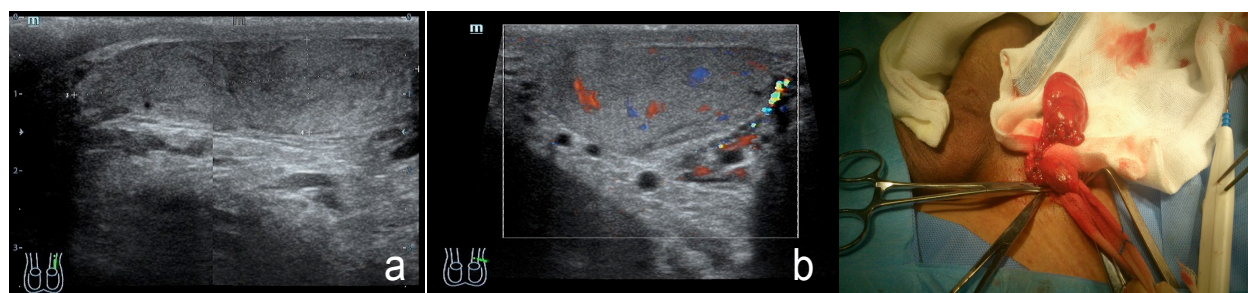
A) Sagittal Sonogram of the Left Hemiscrotum Showing a 4.9x1.2cm, Oval-shaped Mass (Arrows) with Regular Margins Located Superior to the Left testis and Separate from it. The lesion is solid and heterogeneous, with internal areas of hyperechogenicity. B) Color Doppler transverse sonogram of the palpable mass shows intralesional vascularity
